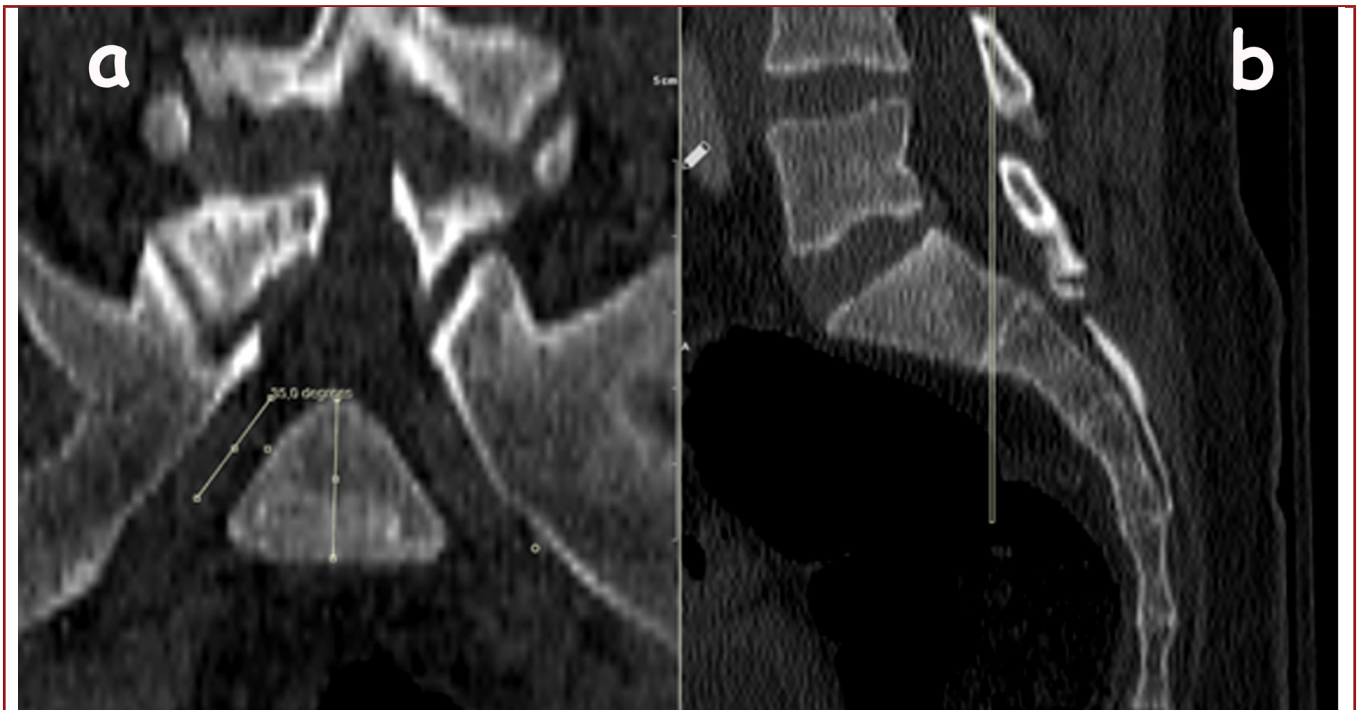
CT of the pelvis a) The coronal view of the USNRT. The tunnel course angle from the midline measured between vertebral corpus vertical line and the USNRT line. b) The sagittal CT section, showing the coronal view orientation which was used to measure the USNRT course angle.
